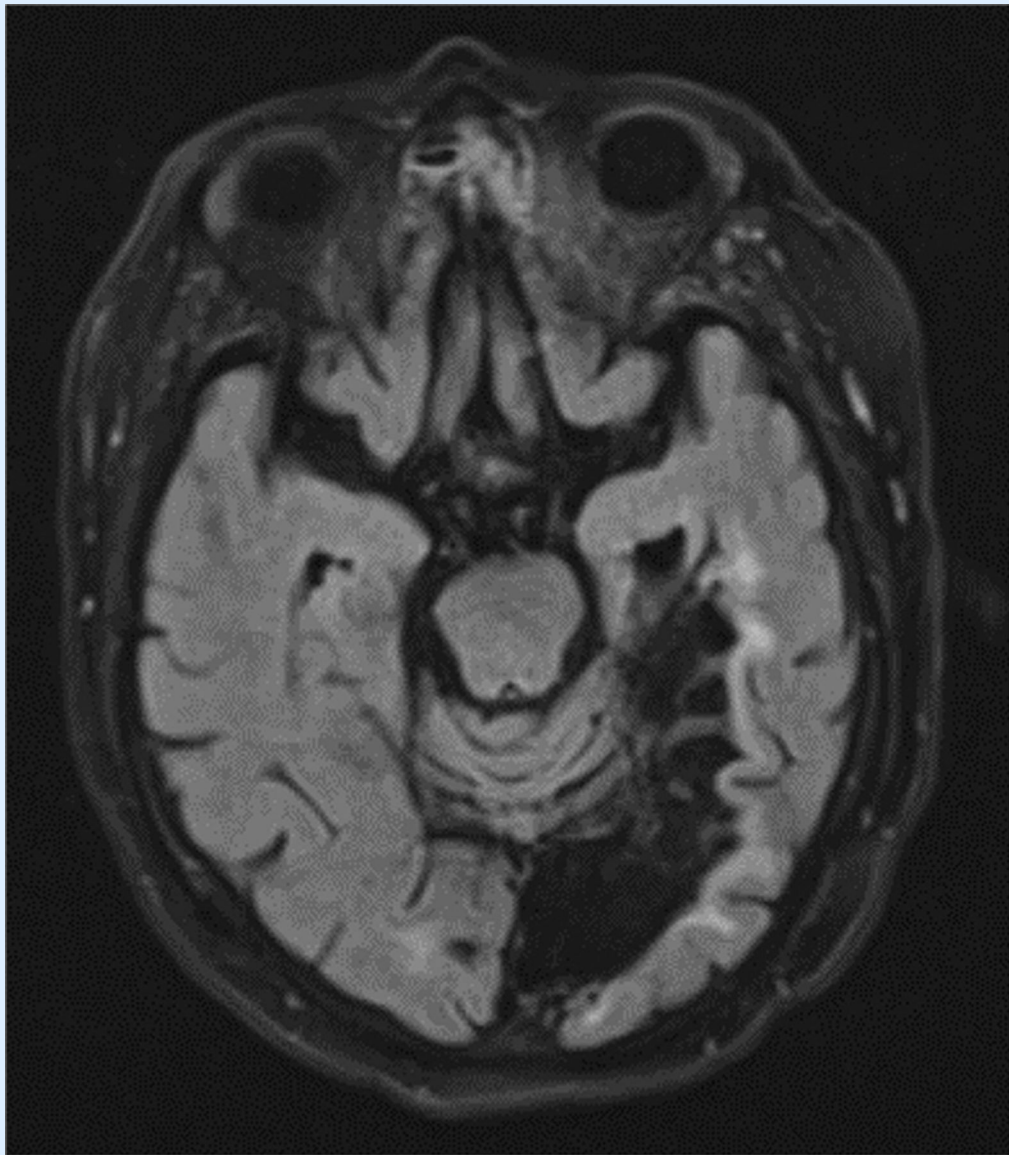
Imaging of the patient in CASE 5-2. Axial fluid-attenuated inversion recovery (FLAIR) MRI shows encephalomalacia in the left posterior cerebral artery territory as well as hippocampal atrophy, left greater than right.
